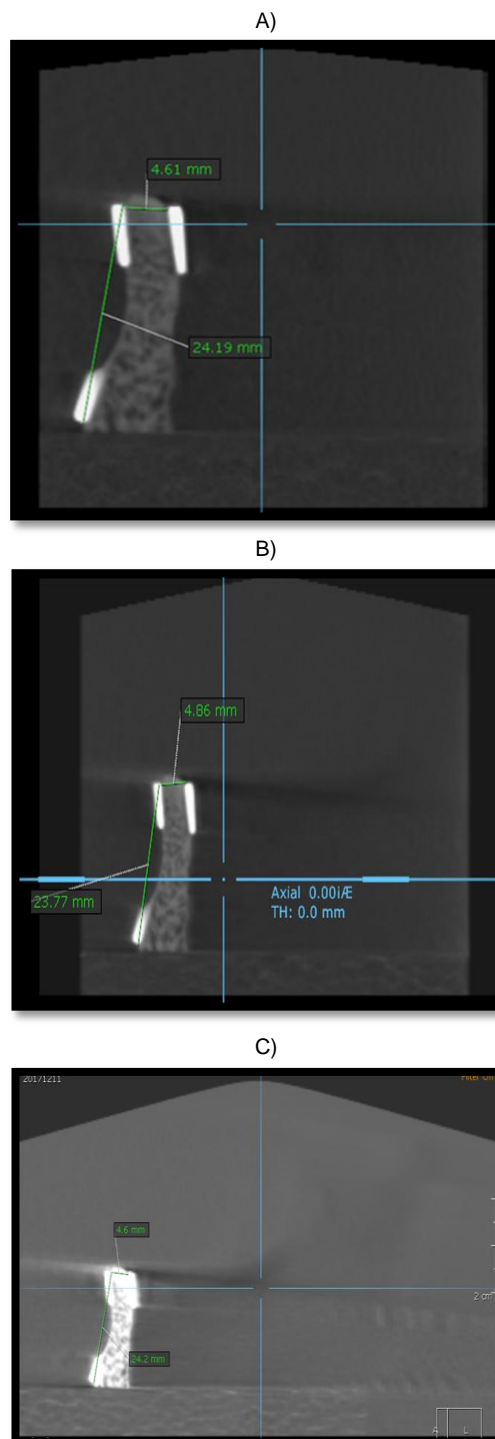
A) CBCT linear measurement of bone height & thickness on Small FOV CBCT images; B) CBCT linear measurement of bone height & thickness on Medium FOV CBCT images; C) CBCT linear measurement of bone height & thickness on Large FOV CBCT images
